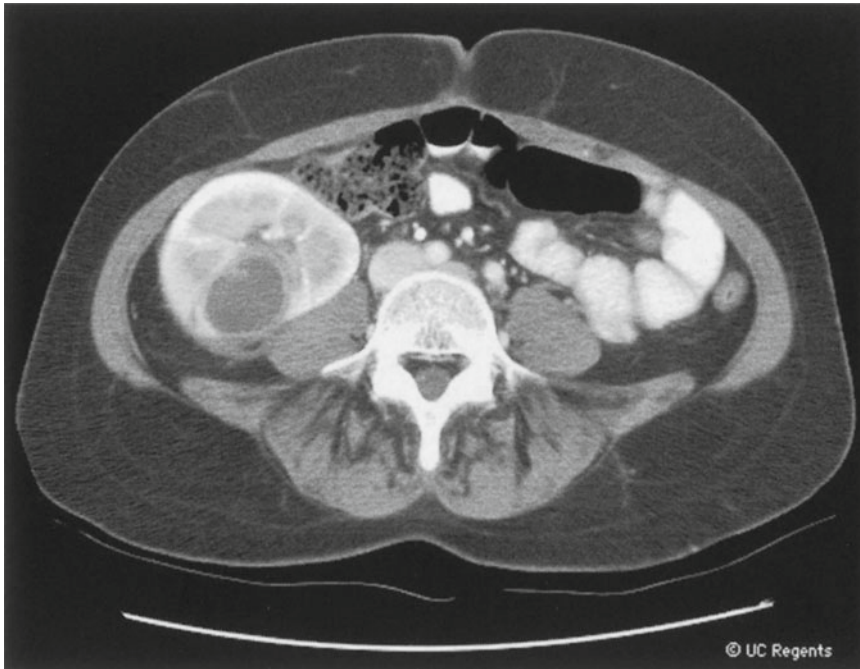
Contrast-enhanced CT with right renal abscess. Note the appearance of the pseudocapsule of the abscess cavity
